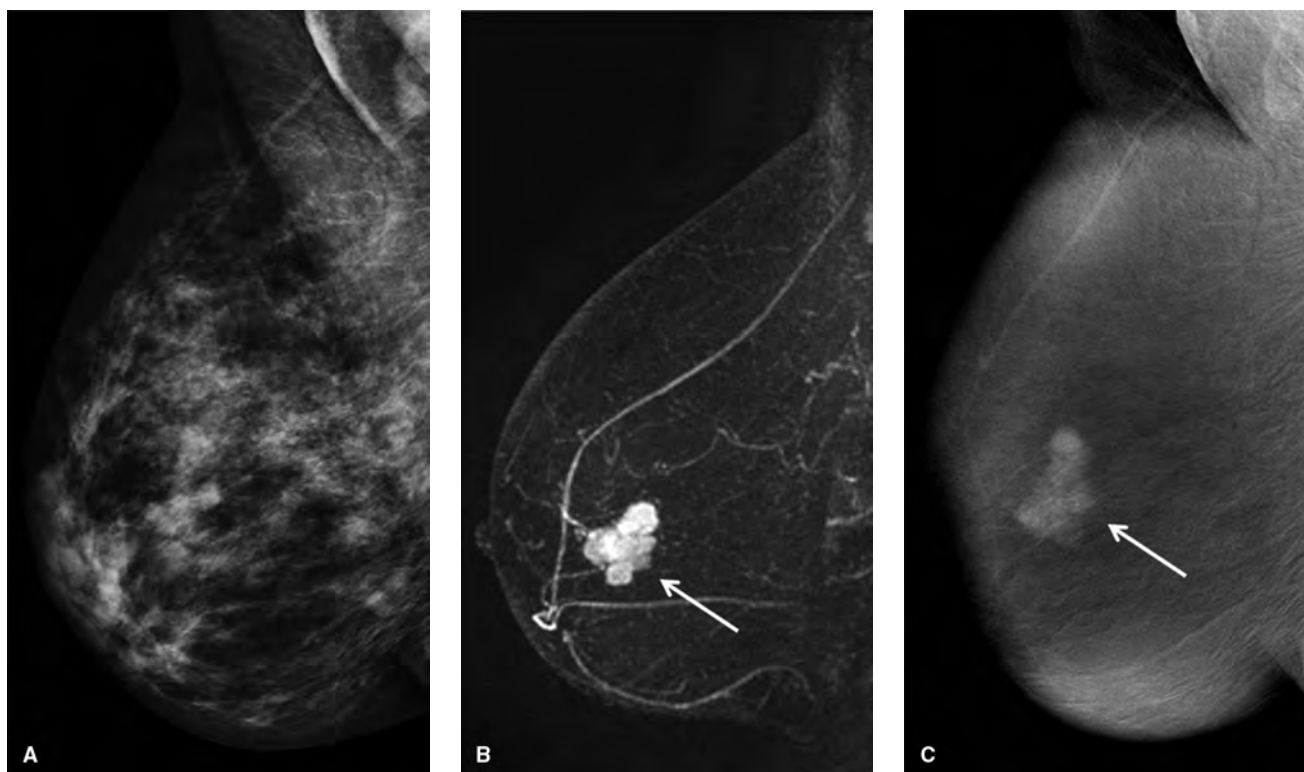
Contrast-enhanced mammography: 51-year-old woman with a palpable mass that was mammographically occult. Cancer detected on ultrasound. (A) Right MLO: negative mammogram. (B) Sagittal subtraction view from breast MRI demonstrates enhancing lobulated breast cancer (*arrow*). (C) Contrast-enhanced mammogram; medio-lateral oblique projection demonstrates lobulated breast cancer similar to MRI (*arrow*).
